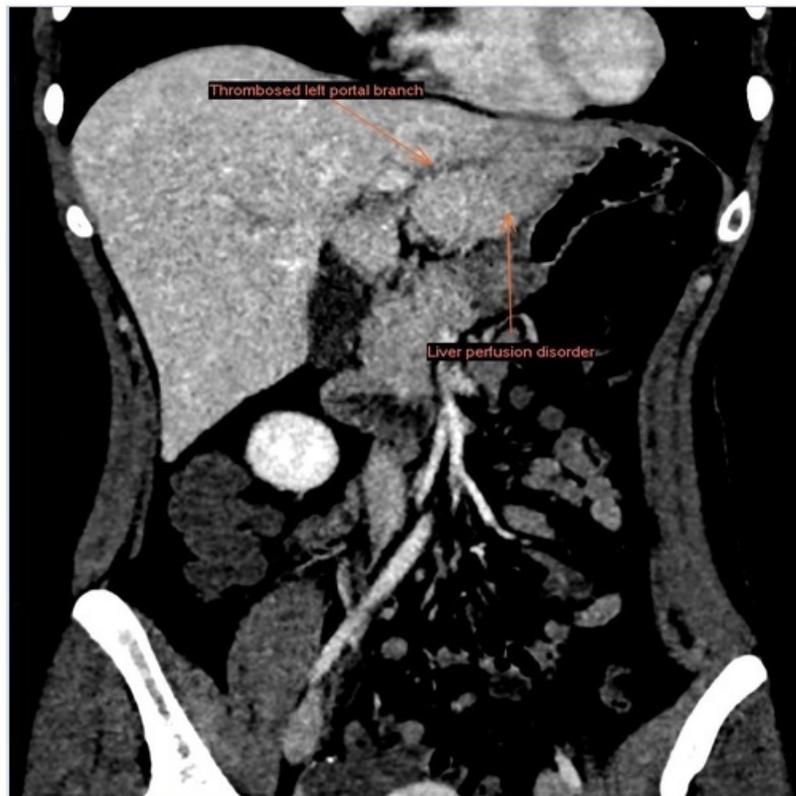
Coronal CT image. Diagnosis of pylephlebitis with impaired perfusion in segment II of the liver
